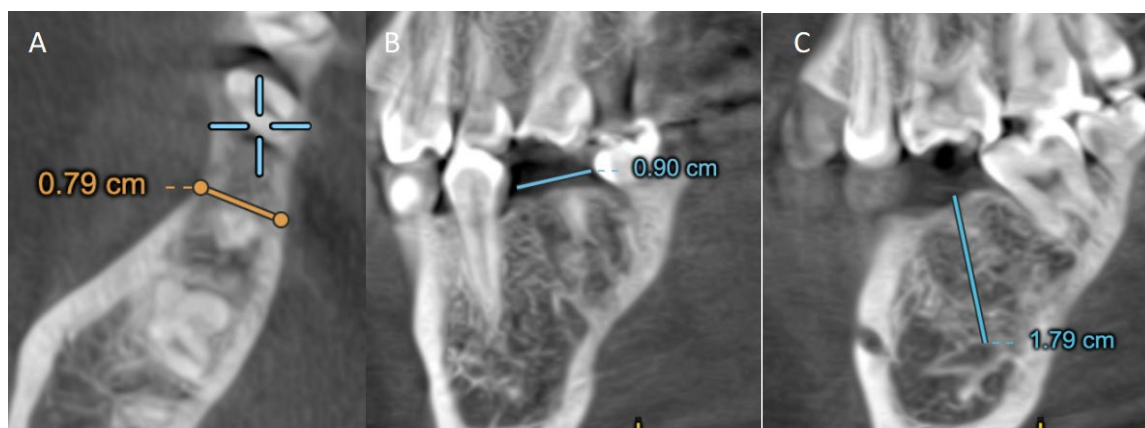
Cone Beam Computed Tomography (CBCT) at 46 region (preoperative). (A)Bone thickness (B)Width (C)Height from the ridge to the inferior alveolar nerve canal.
